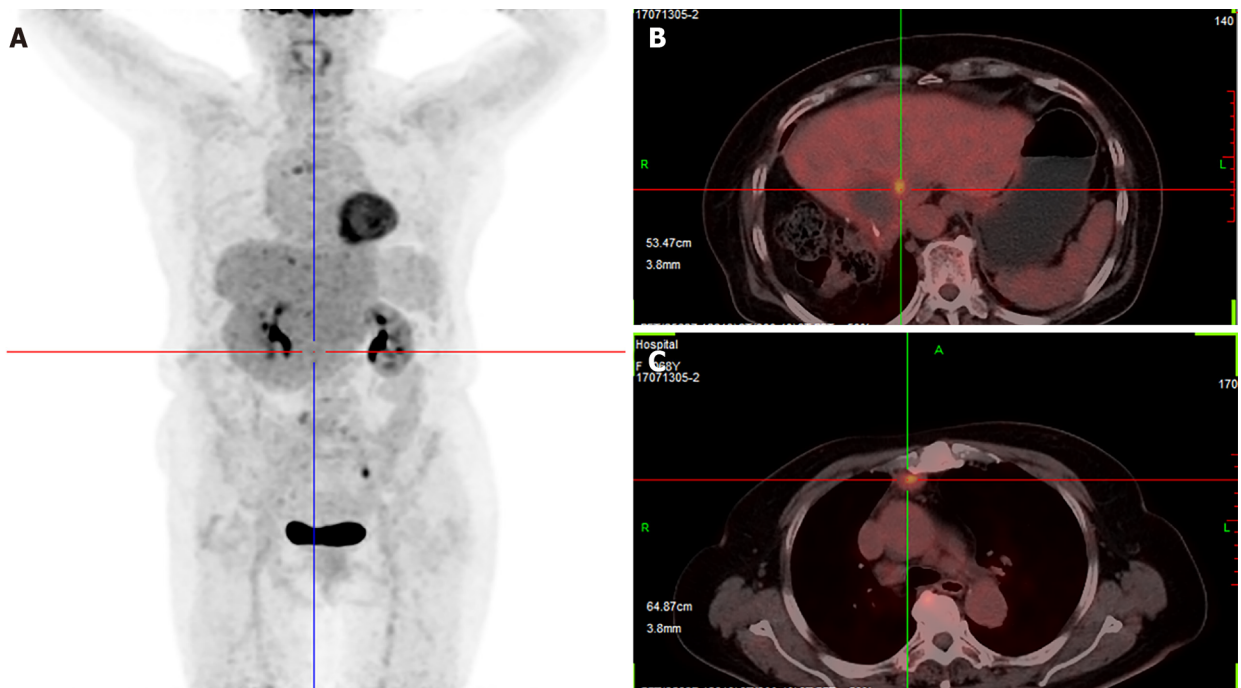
Positron emission tomography-computed tomography. A-C: Multiple metastases had nearly disappeared.
